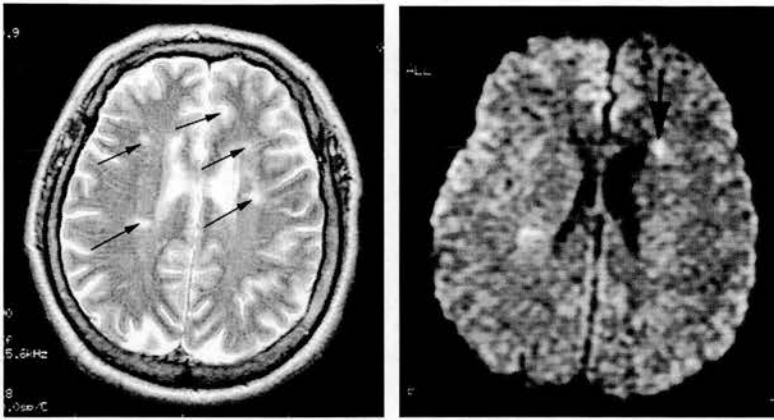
The DWI scan identified an acute lesion amongst several lesions seen on T2 PH246: Presented with left LACS (NIHSS 6). MR performed at 26 hours. The T2 image (left) showed several high signal lesions (arrows), whilst the DWI (right) showed a single left frontal hyperintense lesion (arrow)
